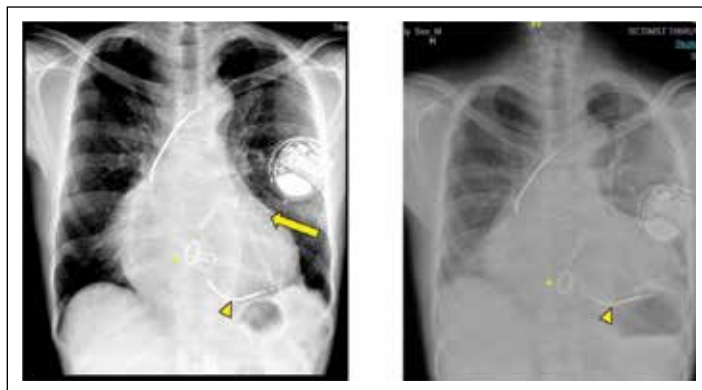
This is a case of post-operative DVR (AVR + TVR with mechanical prosthesis) with multiple hemodynamically unstable VTs requiring resuscitation and Resuscitated cardiac arrest. The tricuspid valve is a mechanical ball-in-cage prosthesis (*), so a dual coil AICD lead was implanted in the middle cardiac vein (arrowhead). For pacing and sensing, another bipolar LV lead (arrow) was implanted in one of the posterolateral venous tributaries and connected to the DF-1 pulse generator. A frontal radiograph of the same is shown for the lead positions.
